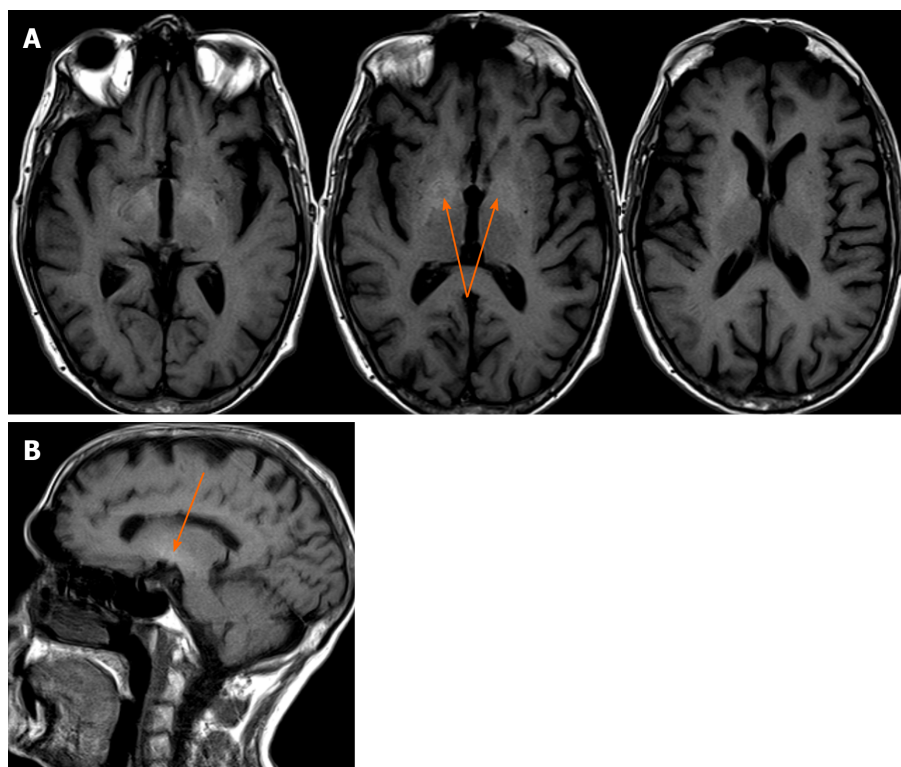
Brain magnetic resonance imaging. A: Axial; B: Sagittal projection showing T1-weighted imaging, hyperintense signal (arrow) within a lentiform nucleus extending into the midbrain.
